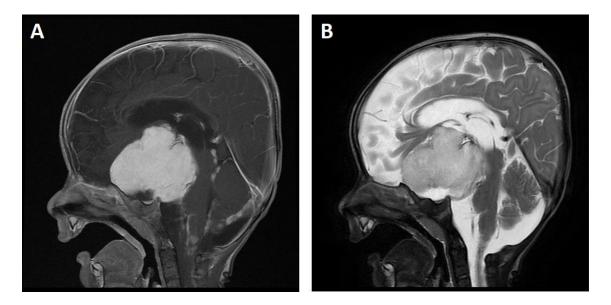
T1-weighted sagittal spin echo (SE) acquisition technique with contrast (+C) (A) and T2-weighted sagittal fast recovery fast spin-echo (FRFSE) (B) magnetic resonance imaging of the patient demonstrating a huge brain tumour, which could not be removed.
